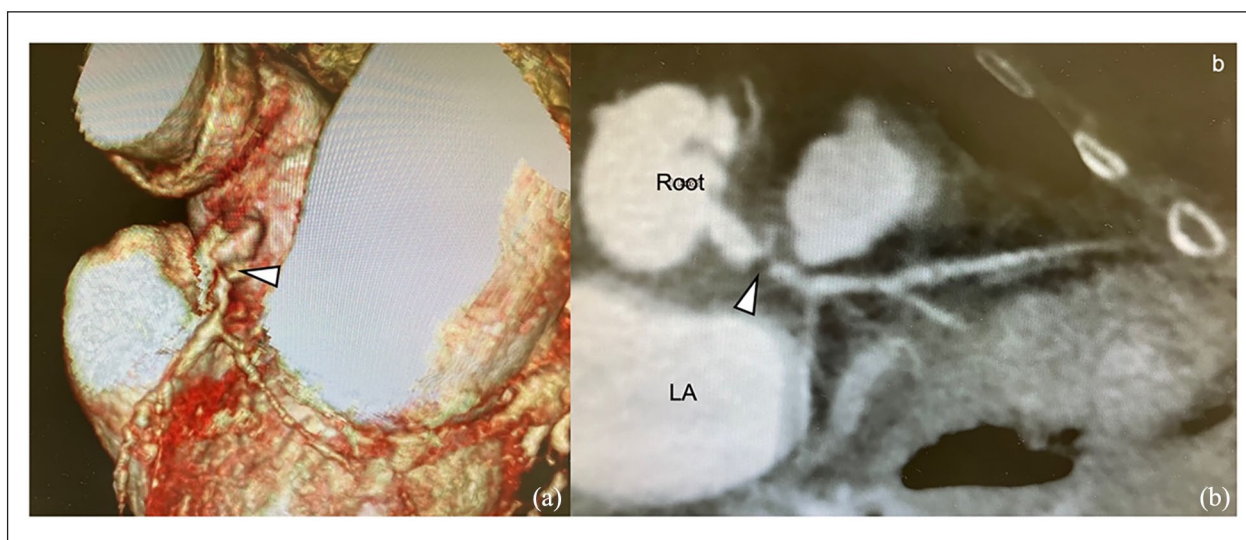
Multidetector computed tomography. (a and b) The white arrowhead indicates stenosis of the grafted portion of the coronary artery. LA indicates left atrium.
